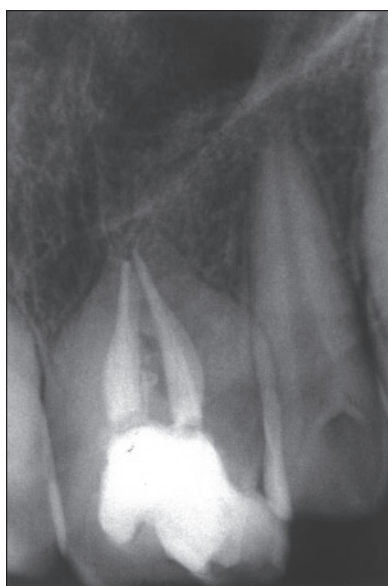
Periapical radiograph after endodontic treatment.
